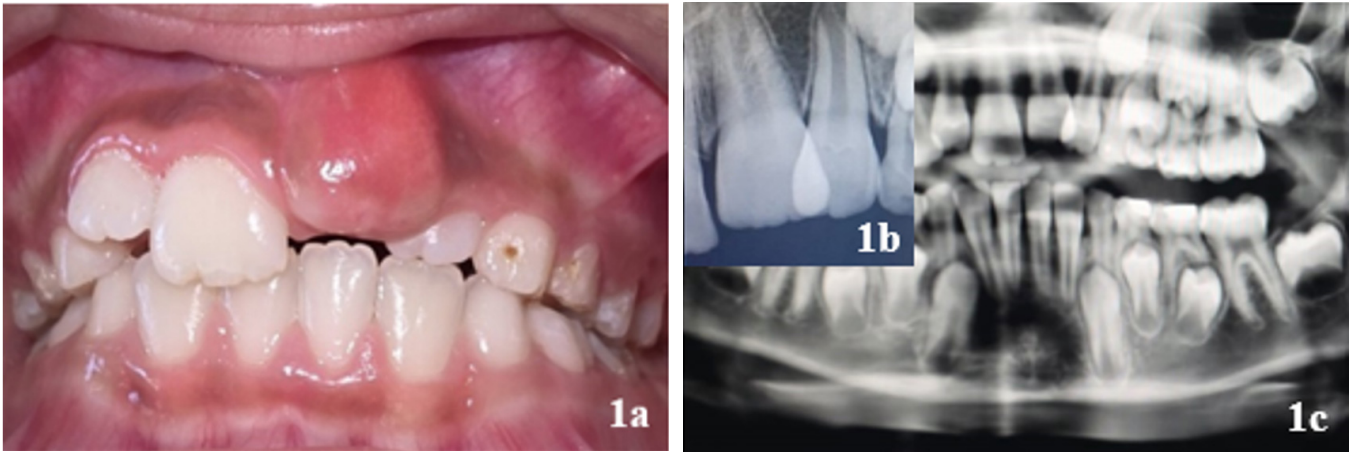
(1a) Pre-operative frontal view showing swelling with respect to #21; (1b) Pre-operative intraoral periapical radiograph showing #21 with open apex; (1c) Orthopantomogram showing unerupted #21 and more advanced #22.
